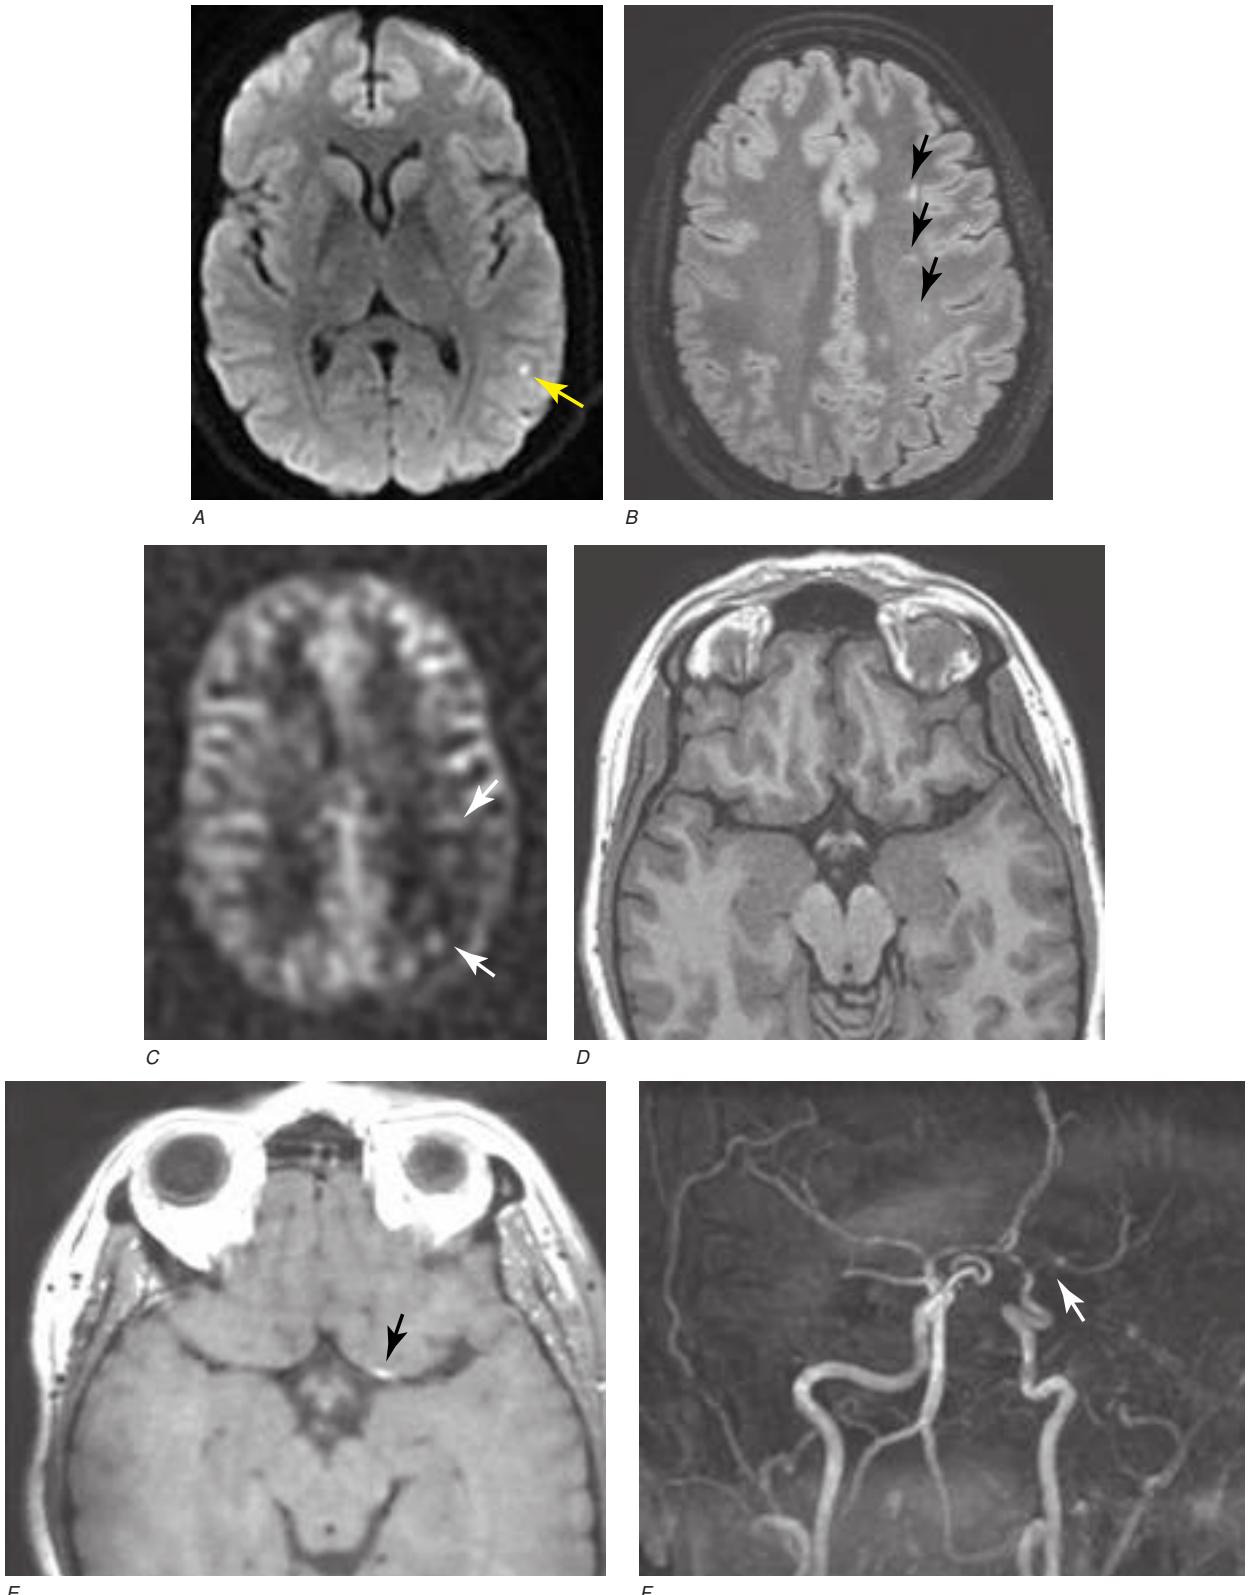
Arterial spin label and vessel wall imaging in a 25-year-old woman with focal cerebral arteriopathy. The patient had an 8-month history of intermittent weakness of the right side with spasms. Imaging shows evidence of cerebral ischemia. CSF was transiently inflammatory. *A*, Diffusion-weighted image shows focal region of reduced diffusion in left parietal lobe. *B*, T2 FLAIR images show several foci of high signal in left deep subcortical white matter. *C*, Arterial spin label image demonstrates reduced cerebral blood flow in left parietal lobe (arrows). *D*, 3D T1 image without contrast administration. *E*, 3D T1-weighted Cube vessel wall image following gadolinium contrast shows focal enhancement of the left proximal middle cerebral artery (arrow). (*F*), 3D TOFMRA shows focal narrowing of the left supraclinoid internal carotid artery (arrow).
